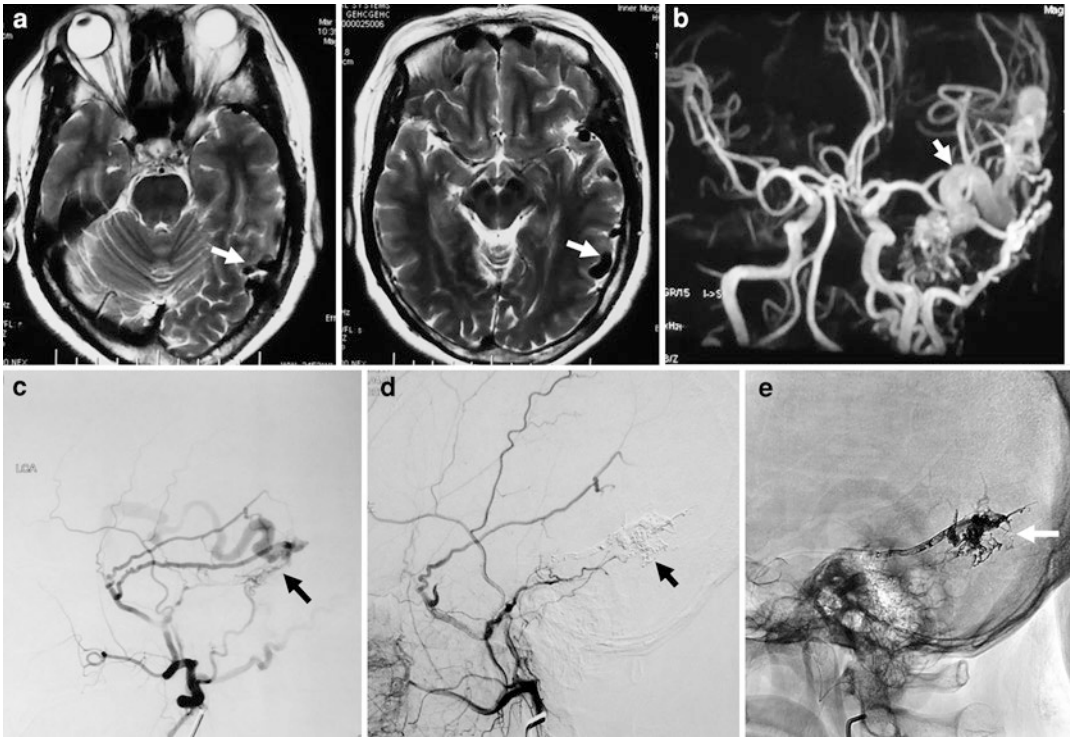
A 50-year-old female patient presented with headaches. (a) Axial MR imaging, T2-weighted, showing flow void signals of cortical veins engorgement in the occipital lobe (arrow). (b) MR angiography (MRA) demonstrate engorgement of the left external carotid arteries and cortical veins of the left occipital lobe. (c) The left external carotid artery angiogram (later view) showing a Zipfel type 3 transverse sinus dural fistula (arrow) supplied by
